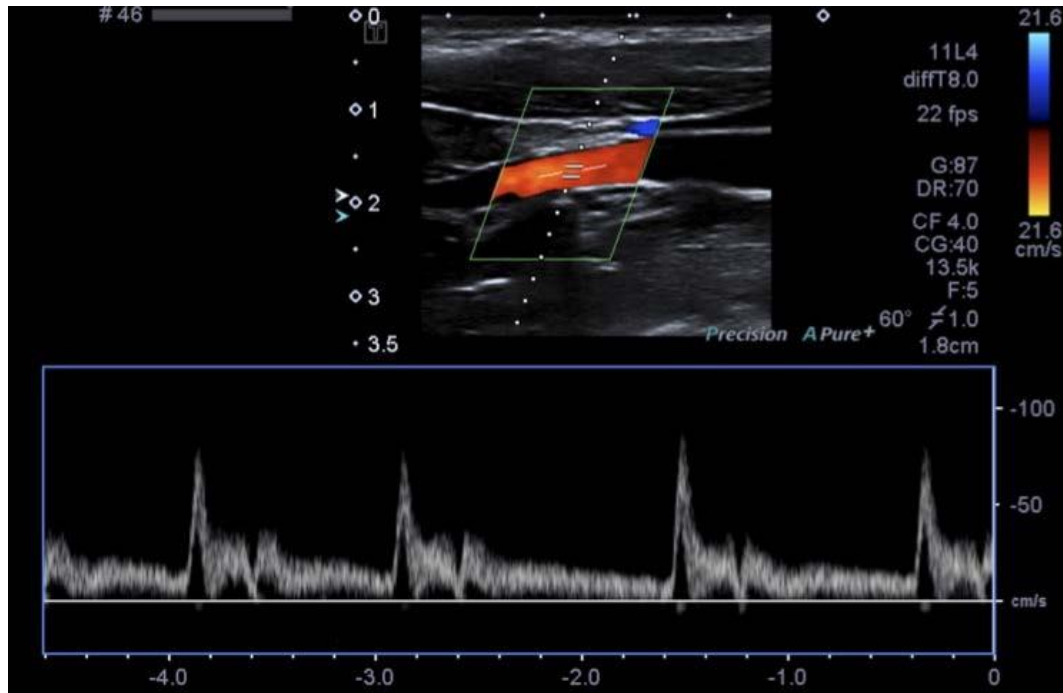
A doppler spectral waveform shown underneath the color doppler. Images reproduced with permission from [56].
